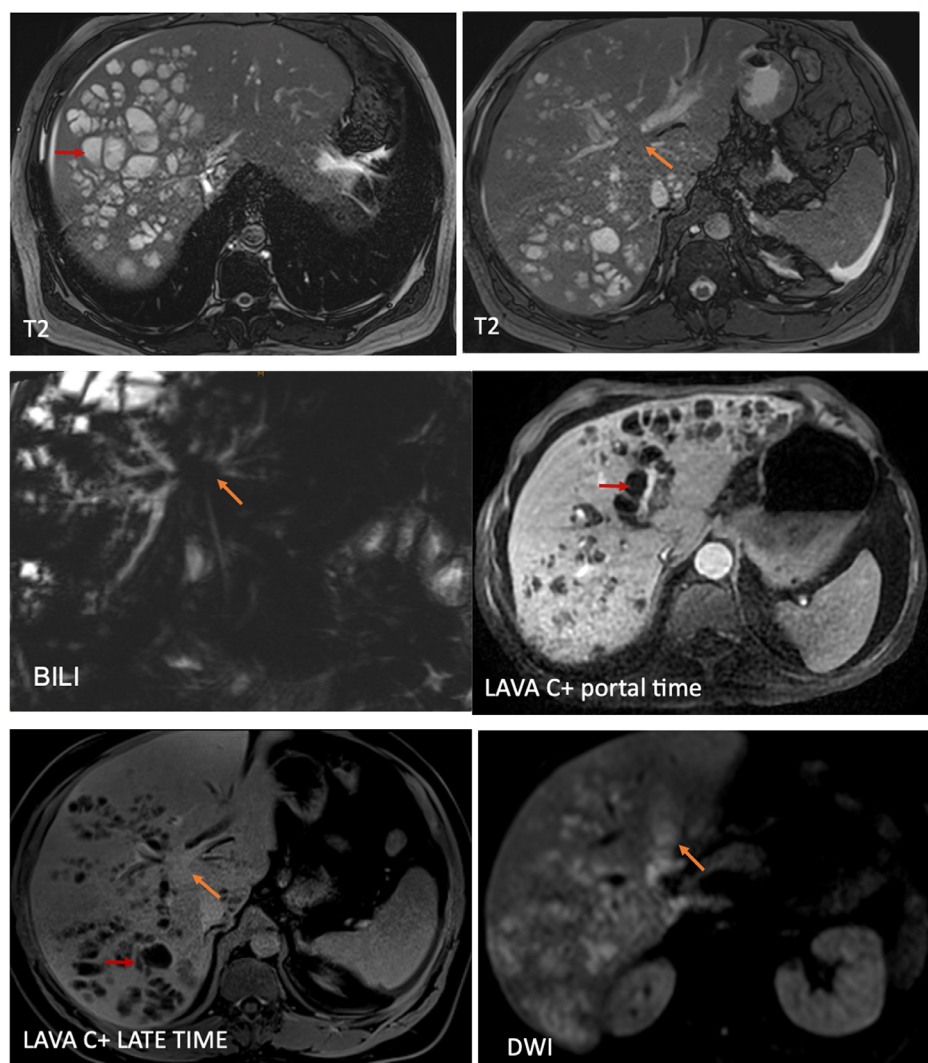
MRI in axial and coronal sections, showing the presence of multiple cystic lesions on either side of the portal branches (red arrow), described in T2 fluid hypersignal, non-restrictive in diffusion, and not enhanced after portal and late contrast. MRCP sequence: dilatation of the intrahepatic bile ducts with right and left disconnection, upstream of a tumor of the hilar plate (orange arrow).
